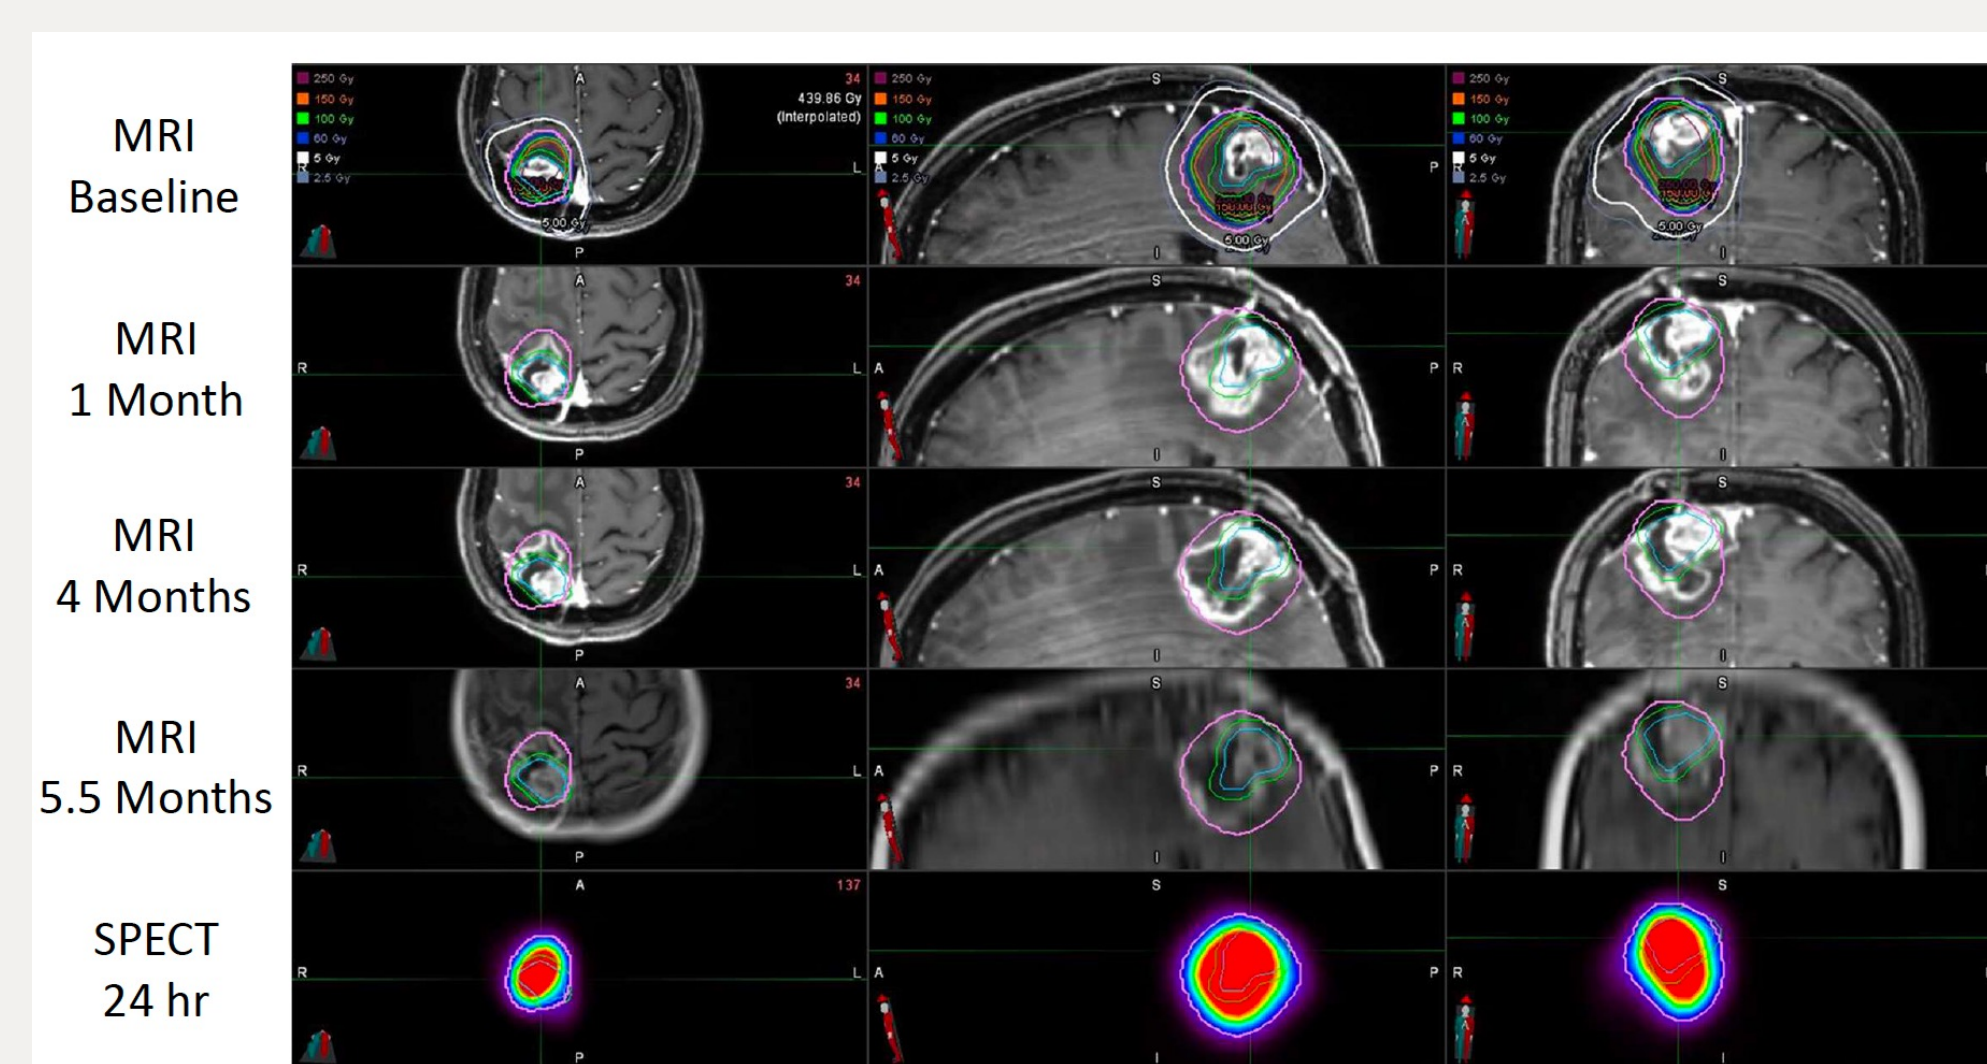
Pretreatment MRI, post treatment MRIs (1, 4, and 5.5 months), and SPECT (24-hours post treatment). Patient is still alive at time of reporting, with OS of 938 days.
